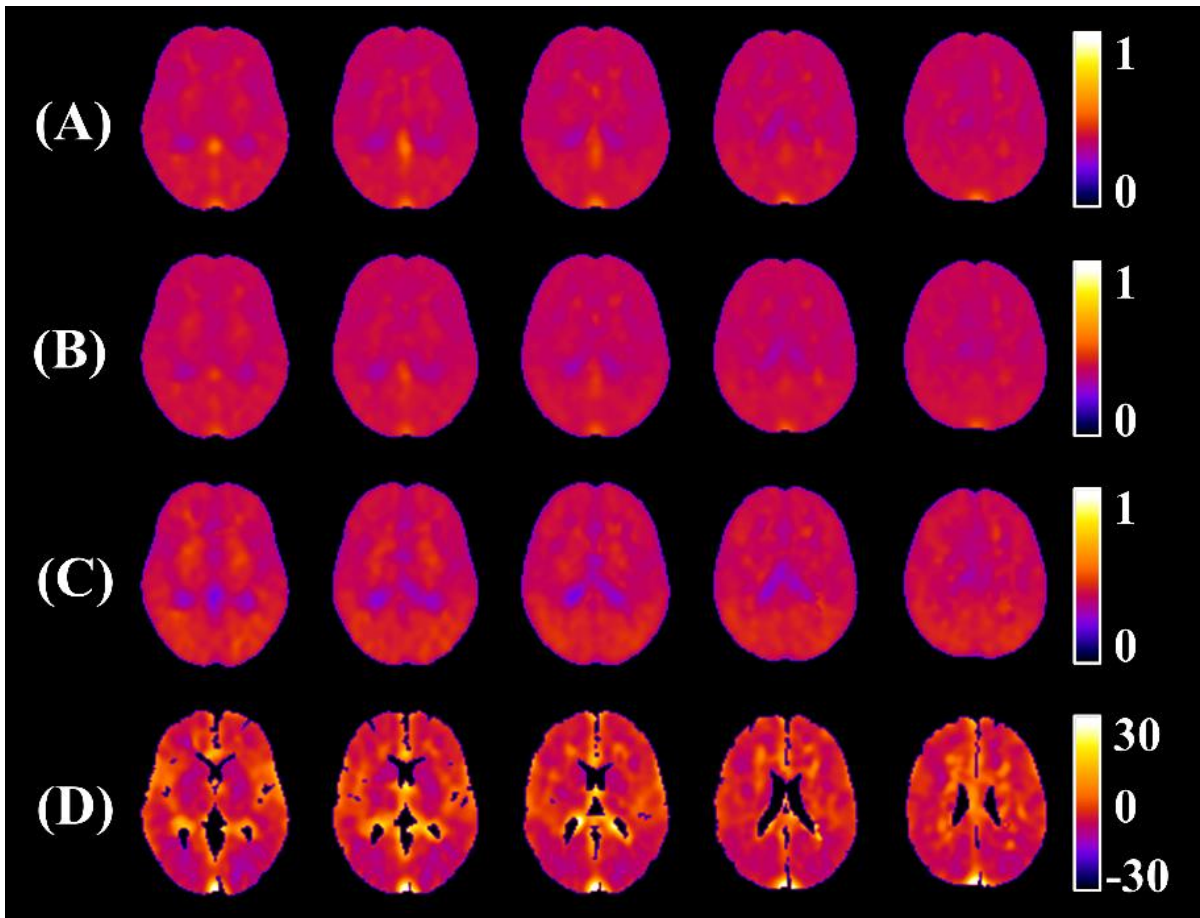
OEF images obtained with the reference-based method. OEF images obtained with the reference-based method for integration times of 3 (A) and 5 min (B), compared to DARG images (C). (D) Images of the relative difference (%) between the 5-min reference-based and DARG OEF images. Non-brain regions were removed by masking the corresponding anatomical T₁-weighted MR images. All images were normalized to the MNI space.
